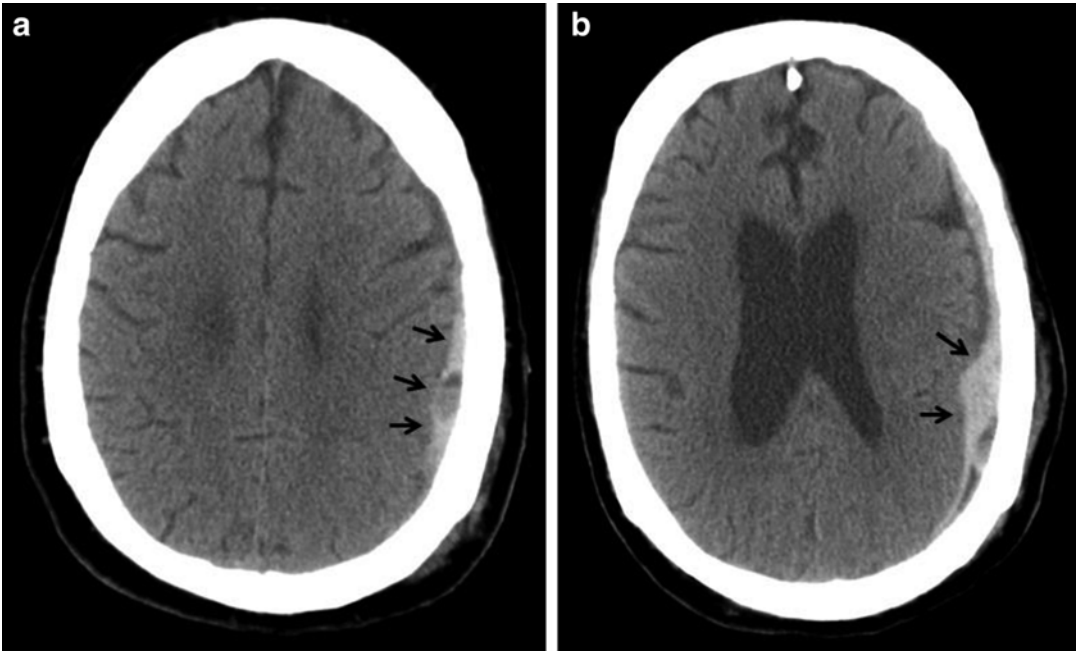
Head CT showing acute subdural hematoma (*black arrows*)
